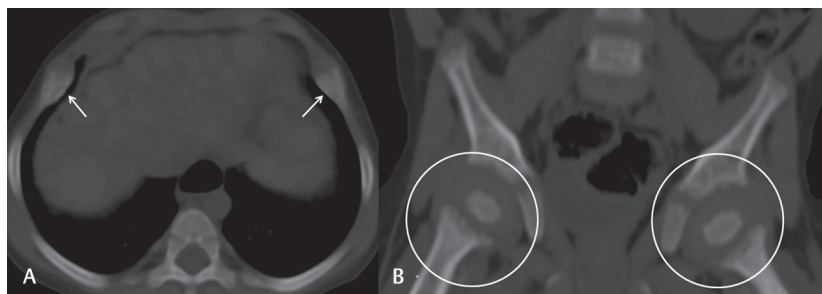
Axial CT cuts in bone window through the lower thorax; bilateral widening of anterior ribs (arrows) at costochondral junctions (A). Cupping, fraying, and splaying of bilateral upper femora metaphyses (encircled) are shown in coronal CT in bone window of pelvis (B). Findings are typical of rickets.
